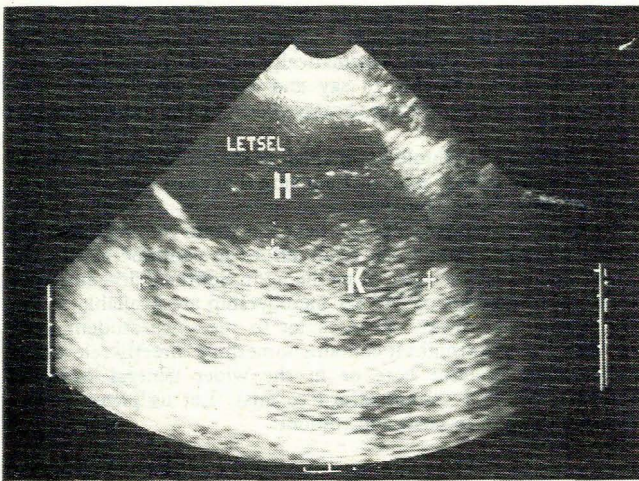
Ultrasound scan showing haematoma posterolateral to the left kidney, displacing it anteriorly (K = kidney; H = haematoma).
